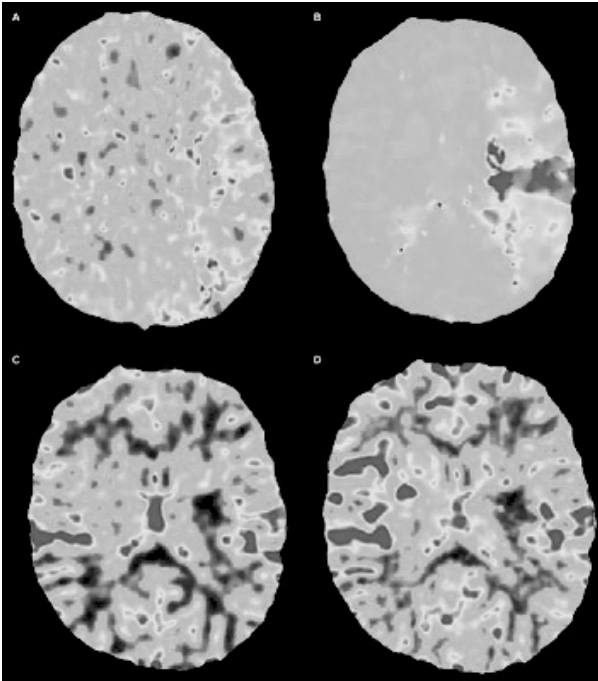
CT perfusion map. Axial CT perfusion shows an extensive area of the left middle cerebral artery territory with increased mean transit time (A) and time-to-peak (B), while only a limited area shows a decreased cerebral blood volume (C) and flow (D), suggesting a favourable penumbral pattern.
